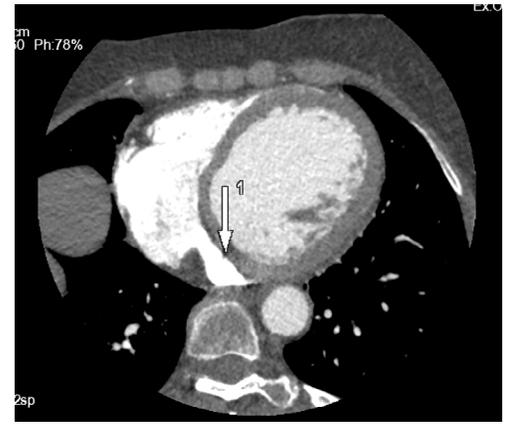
CTA imaging showing PLSVC highlighted by the arrow
